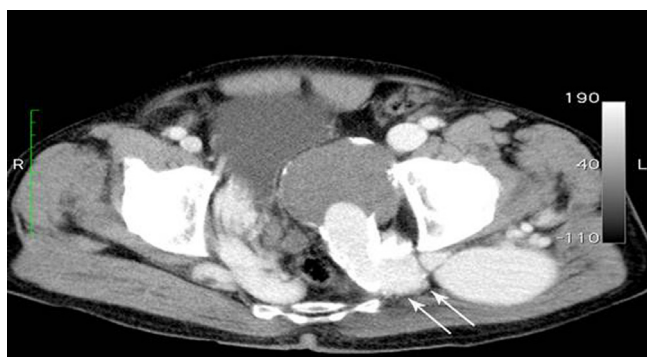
Axial CT image shows diffuse enlarged vascular collateral veins related to the arterio-venous malformation pressing on the left sciatic nerve at the level of great sciatic foramen (arrows).
